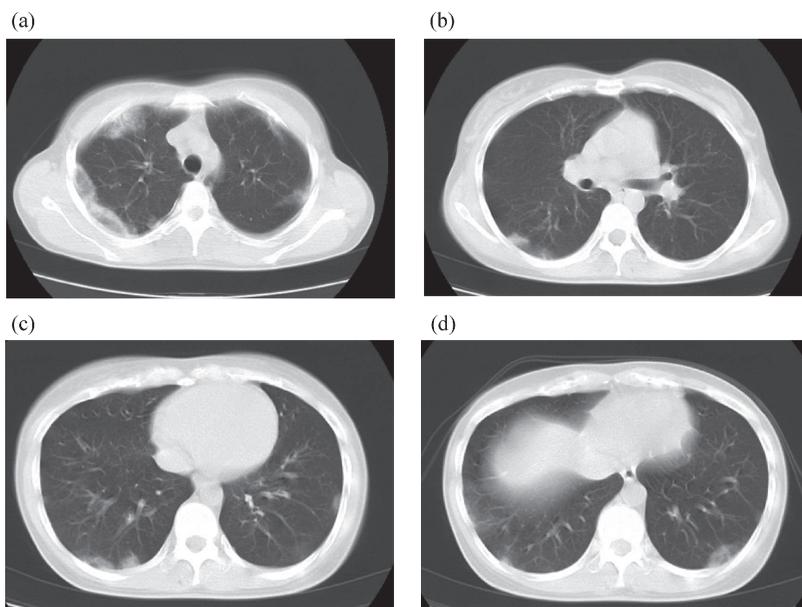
Computed tomography of the chest during the first hospital visit
